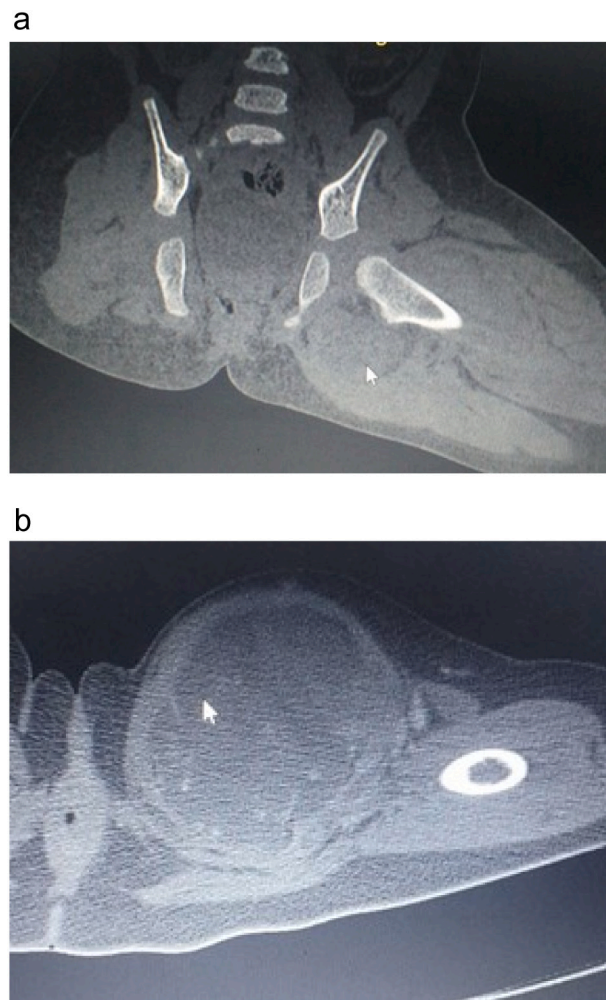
a Showing preoperative CT scan of well circumscribed left anteromedial thigh mass.
